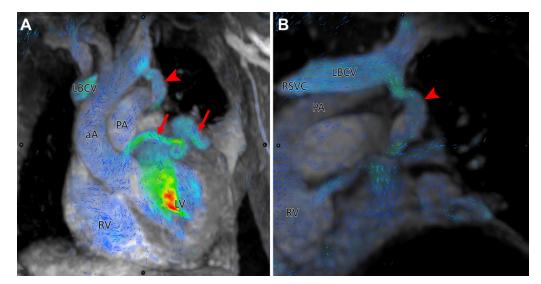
(A, B) Oblique reconstructions of cardiac four-dimensional flow MRI demonstrate retrograde (cephalad) blood flow through the persistent left superior vena cava (red arrowhead) into the left brachiocephalic vein (LBCV). Red arrows indicate left circumflex artery. See Movie 4 (for A) and Movie 5 (for B) for full loop. aA = ascending aorta, LV = left ventricle, PA = pulmonary artery, RSVC = right superior vena cava, RV = right ventricle.
